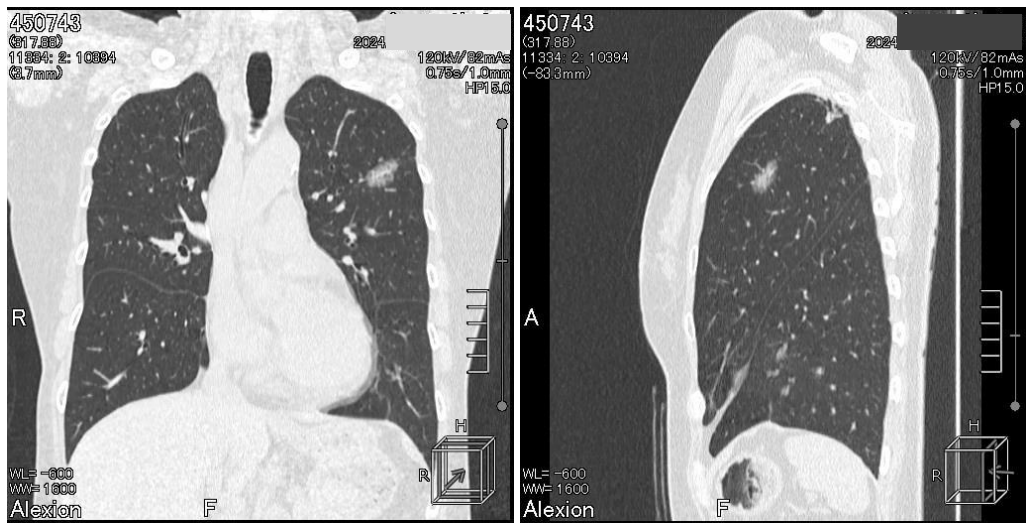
Findings of the lung by CT scan
